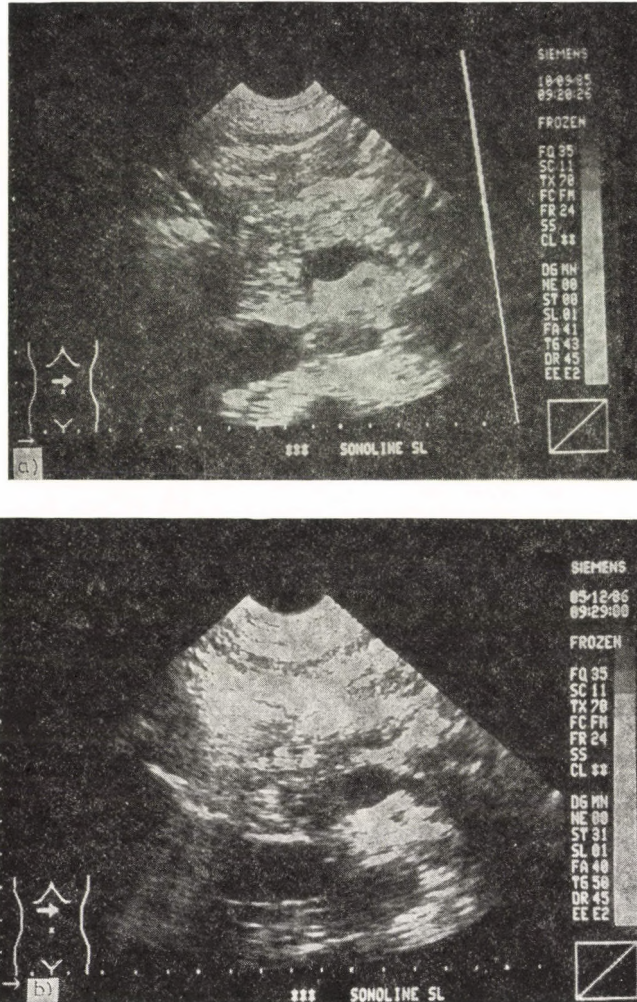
Sonographic scan of MJ., a 53-year-old male patient, following a decompressive operation. *A.* Half-a-year postoperatively, there is no evidence of obstruction, the enlargement and inhomogeneity of the pancreatic parenchyma are essentially reduced with no stones detectable in the pancreatic duct of normal calibre, but with persisting calcification in the parenchyma. *B.* Ultrasonographic picture of a patient of good general condition with no evidence of progression not even one-and-a-half year after operation
